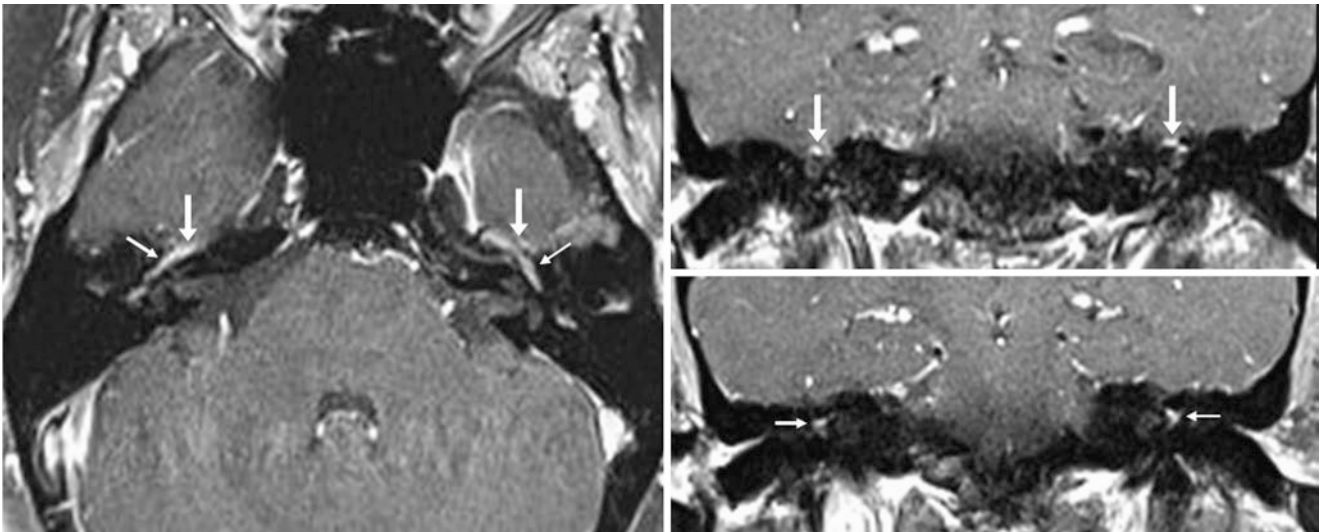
A 38-year-old patient with an orbit protocol MRI at 3 T. Postcontrast FS SET1WIs in the axial (*left*) and coronal (*right*) planes depict avid, bilateral normal enhancement of the geniculate
